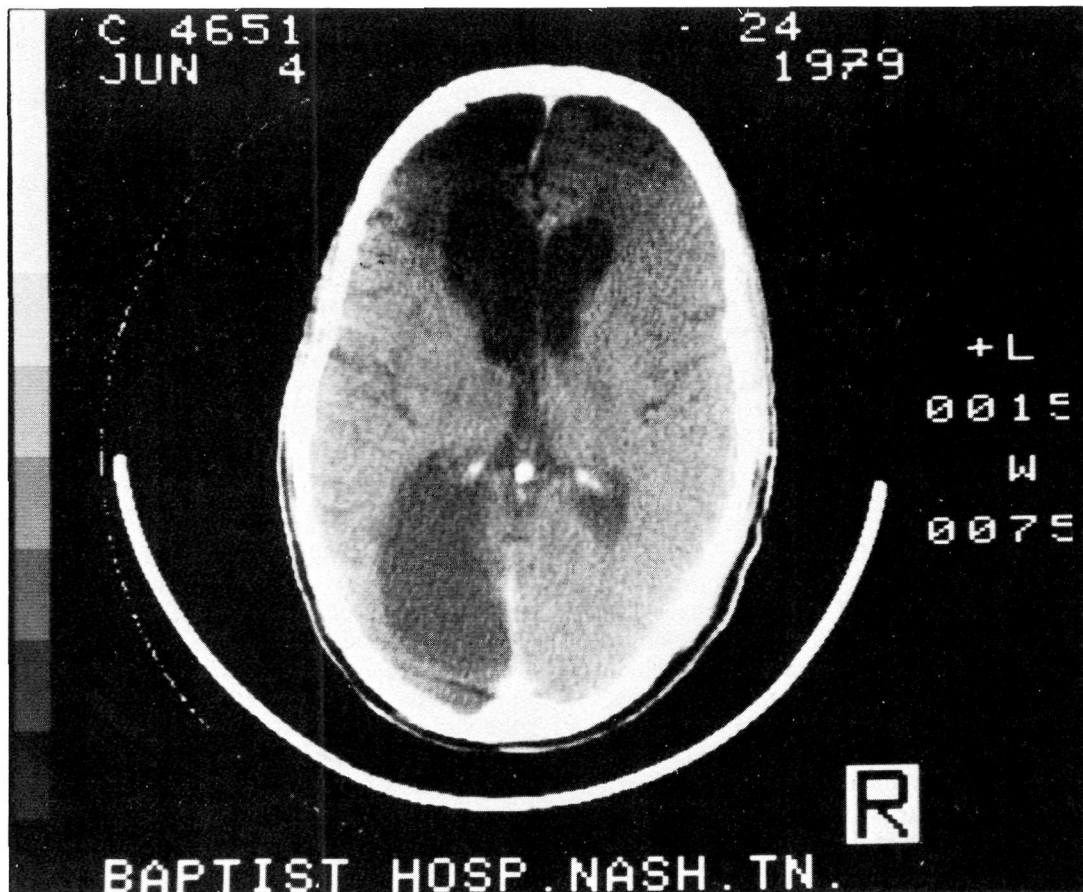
CT Scan photograph showing left frontal and left occipital areas of reduced attenuation.
